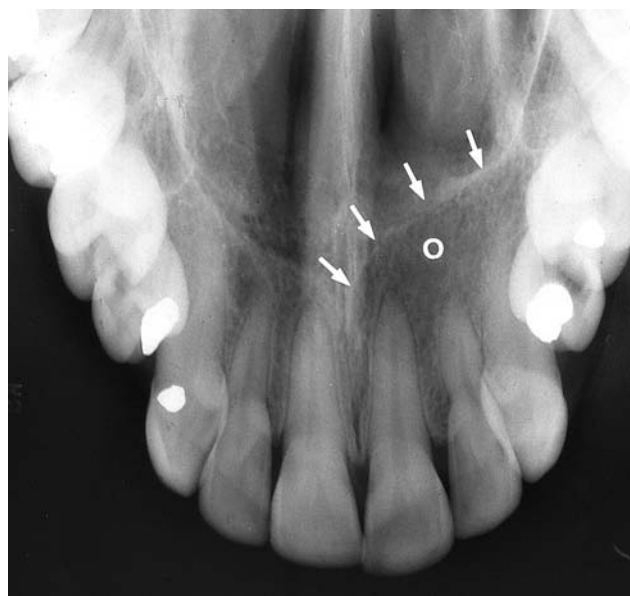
Standard occlusal radiograph of a patient with a nasolabial cyst. There is a posterior convexity of the left half of the radiopaque line that forms the bony border of the nasal aperture. (Courtesy of Drs L.E.M. Chinellato and J.H. Damante.)
